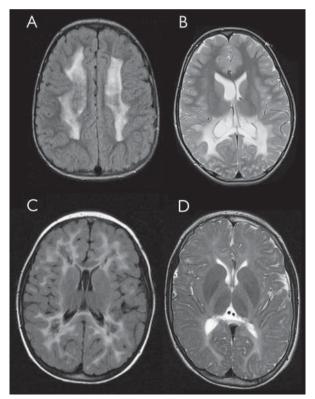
Appearances of four leukoencephalopathies(A) Typical deep, periventricular distribution of clearly leukodystrophic change with sparing of U fibres in metachromatic leukodystrophy. (B) Posterior predominant confluent changes of X-linked adrenoleukodystrophy. (C) FLAIR image showing diffuse white matter involvement (involving U fibres) with emerging cavitation in CACH/VWM disease. (D) Global hypomyelination in Pelizaeus–Merzbacher disease.
